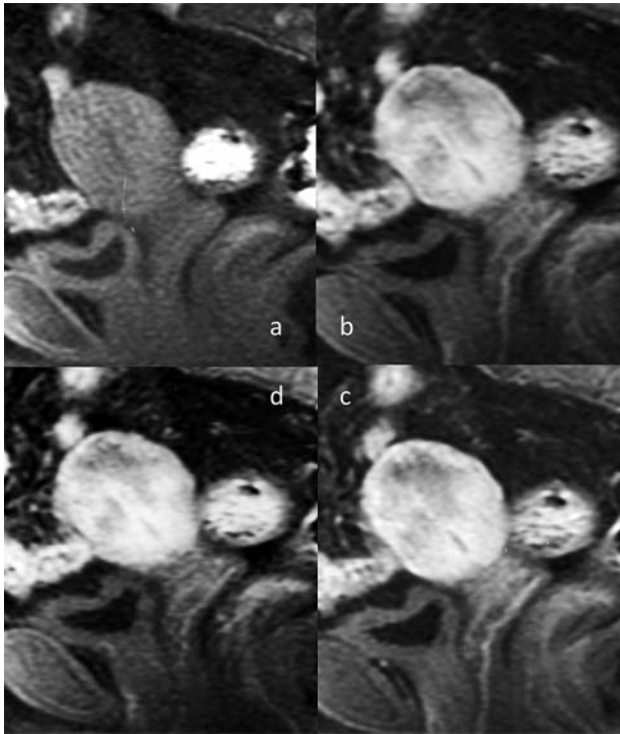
Sagittal T1 weighted dynamic contrast-enhanced magnetic resonance imaging. (a) pre-gadolinium infusion. (b) 30 seconds post-infusion. (c) 60 seconds post-infusion. (d) 120 seconds post-infusion.
